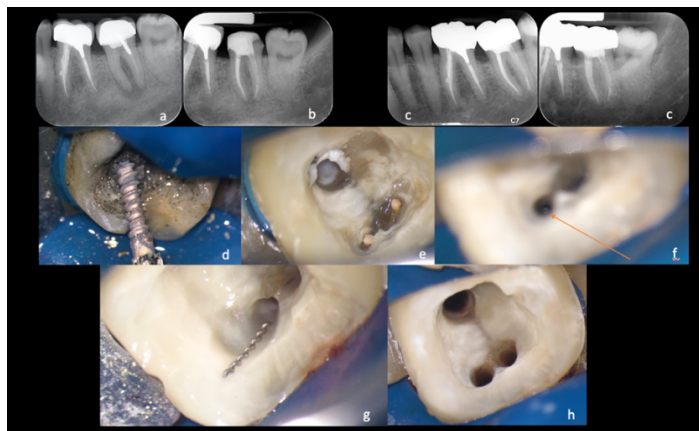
a) Pre-operative x-ray; b) Post-operative x-ray; c) 3-year follow-up (mesial/distal view); d) Metal post removal; e) Post space view; f) Mesial fractured instrument; g) Broken instrument removal; h) Cavity before obturation (the two mesial orifices are observable, there are no significant differences in tissue involvement between the two canal entrances).
